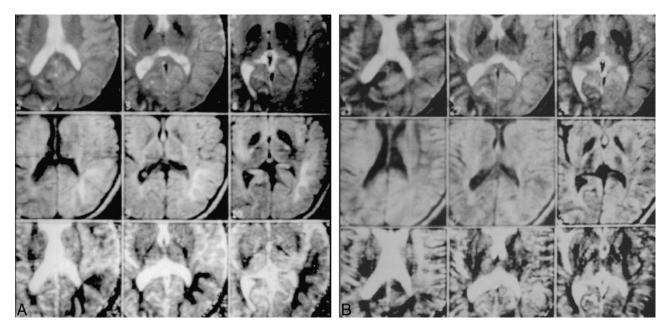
A*, T2-weighted (*top*) and diffusion-weighted (*middle*) as well as ADC map (*bottom*) obtained 11 hours after onset of symptoms show normal T2 and abnormal diffusion (*hyperintensity*). ADC findings (*hypointensity*) are in the left parietal lobe of the ADC map. *B*, T2-weighted (*top*) and diffusion-weighted images (*middle*) and ADC map (*bottom*) obtained 35 hours after onset of symptoms show disappearance of the abnormality previously noted on diffusion-weighted image and ADC map obtained at 11 hours (*A*) and persistent normal T2. These imaging findings are consistent with the resolution of clinical symptoms.
